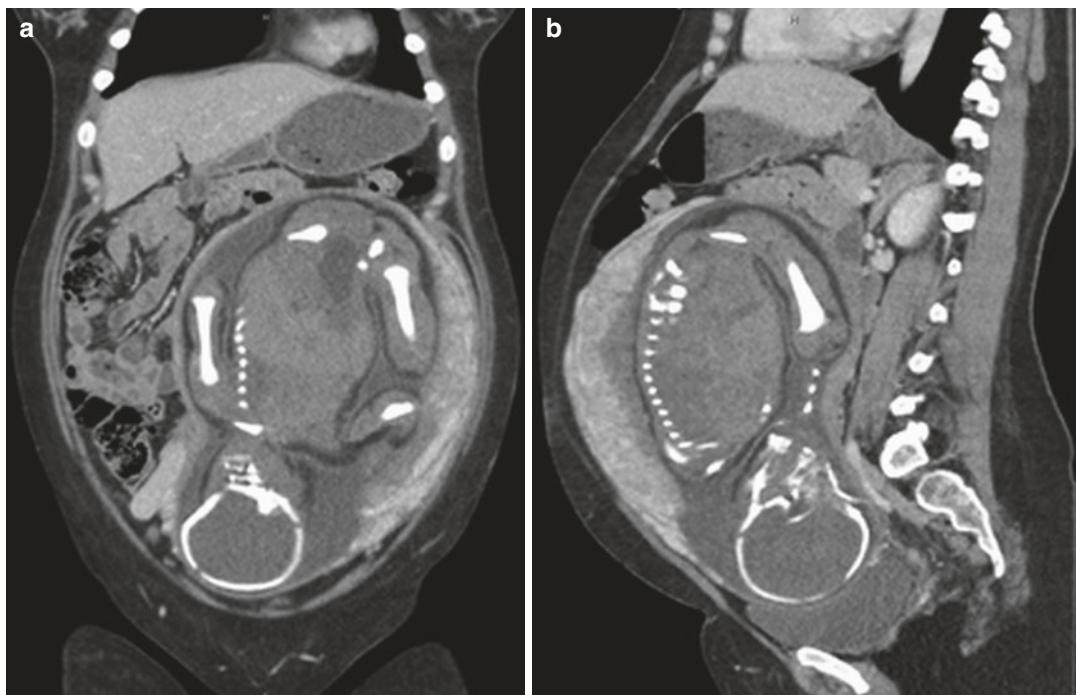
CT scan of a pregnant trauma patient. Especially in the third trimester, displacement of maternal organs occurs as the gravid uterus enlarges. Photo credit: Lee Myers, MD
